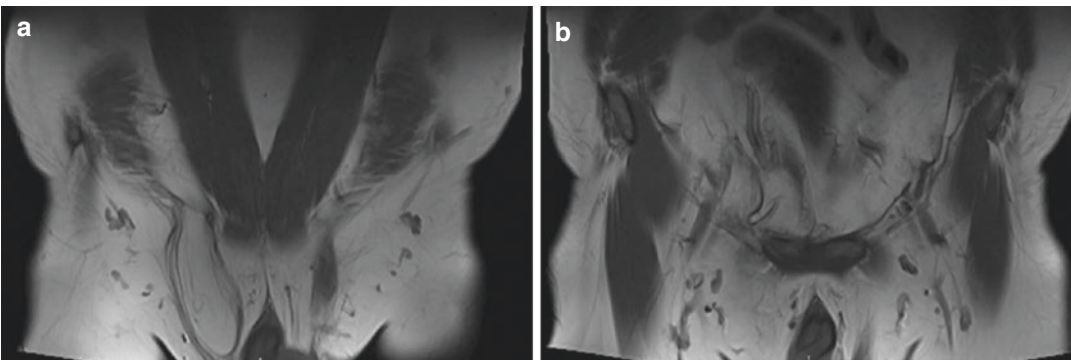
MRI pelvis coronal view of right inguinal hernia recurrence with large preperitoneal fat extending into scrotum (a) due to folding of preperitoneal mesh (b) with possible meshoma as a cause of postoperative chronic pain
